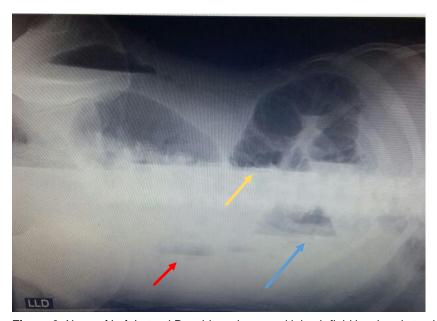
X-ray of Left Lateral Decubitus shows multiple air fluid level and step ladder pattern
